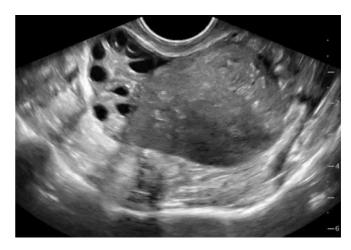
Polycystic ovary seen on transvaginal ultrasound. Note that transvaginal ultrasound should be performed to make the diagnosis, and polycystic ovaries should contain ≥26 follicles. Slowly fanning through the ovary will facilitate counting the number of follicles.
